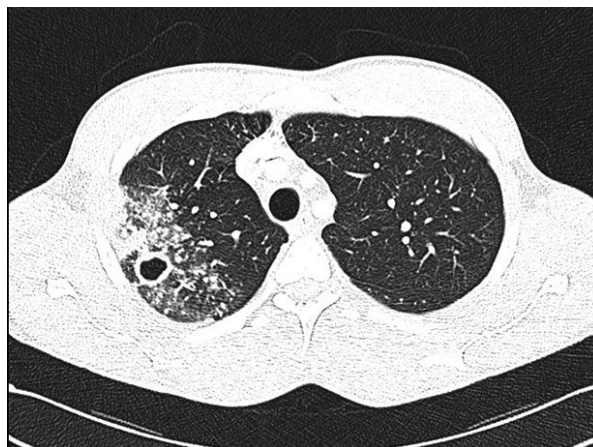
Chest CT. Thick-walled cavitary lesion in the second right segment
